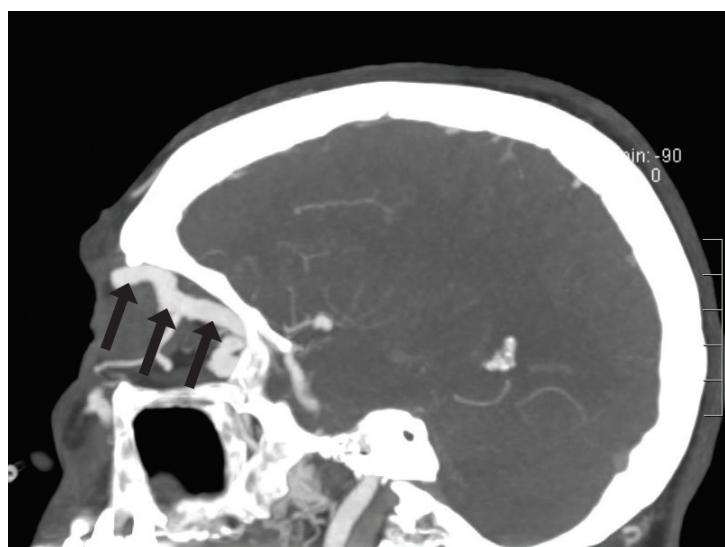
The patient's CTA imaging demonstrates an enlarged left superior ophthalmic vein.
